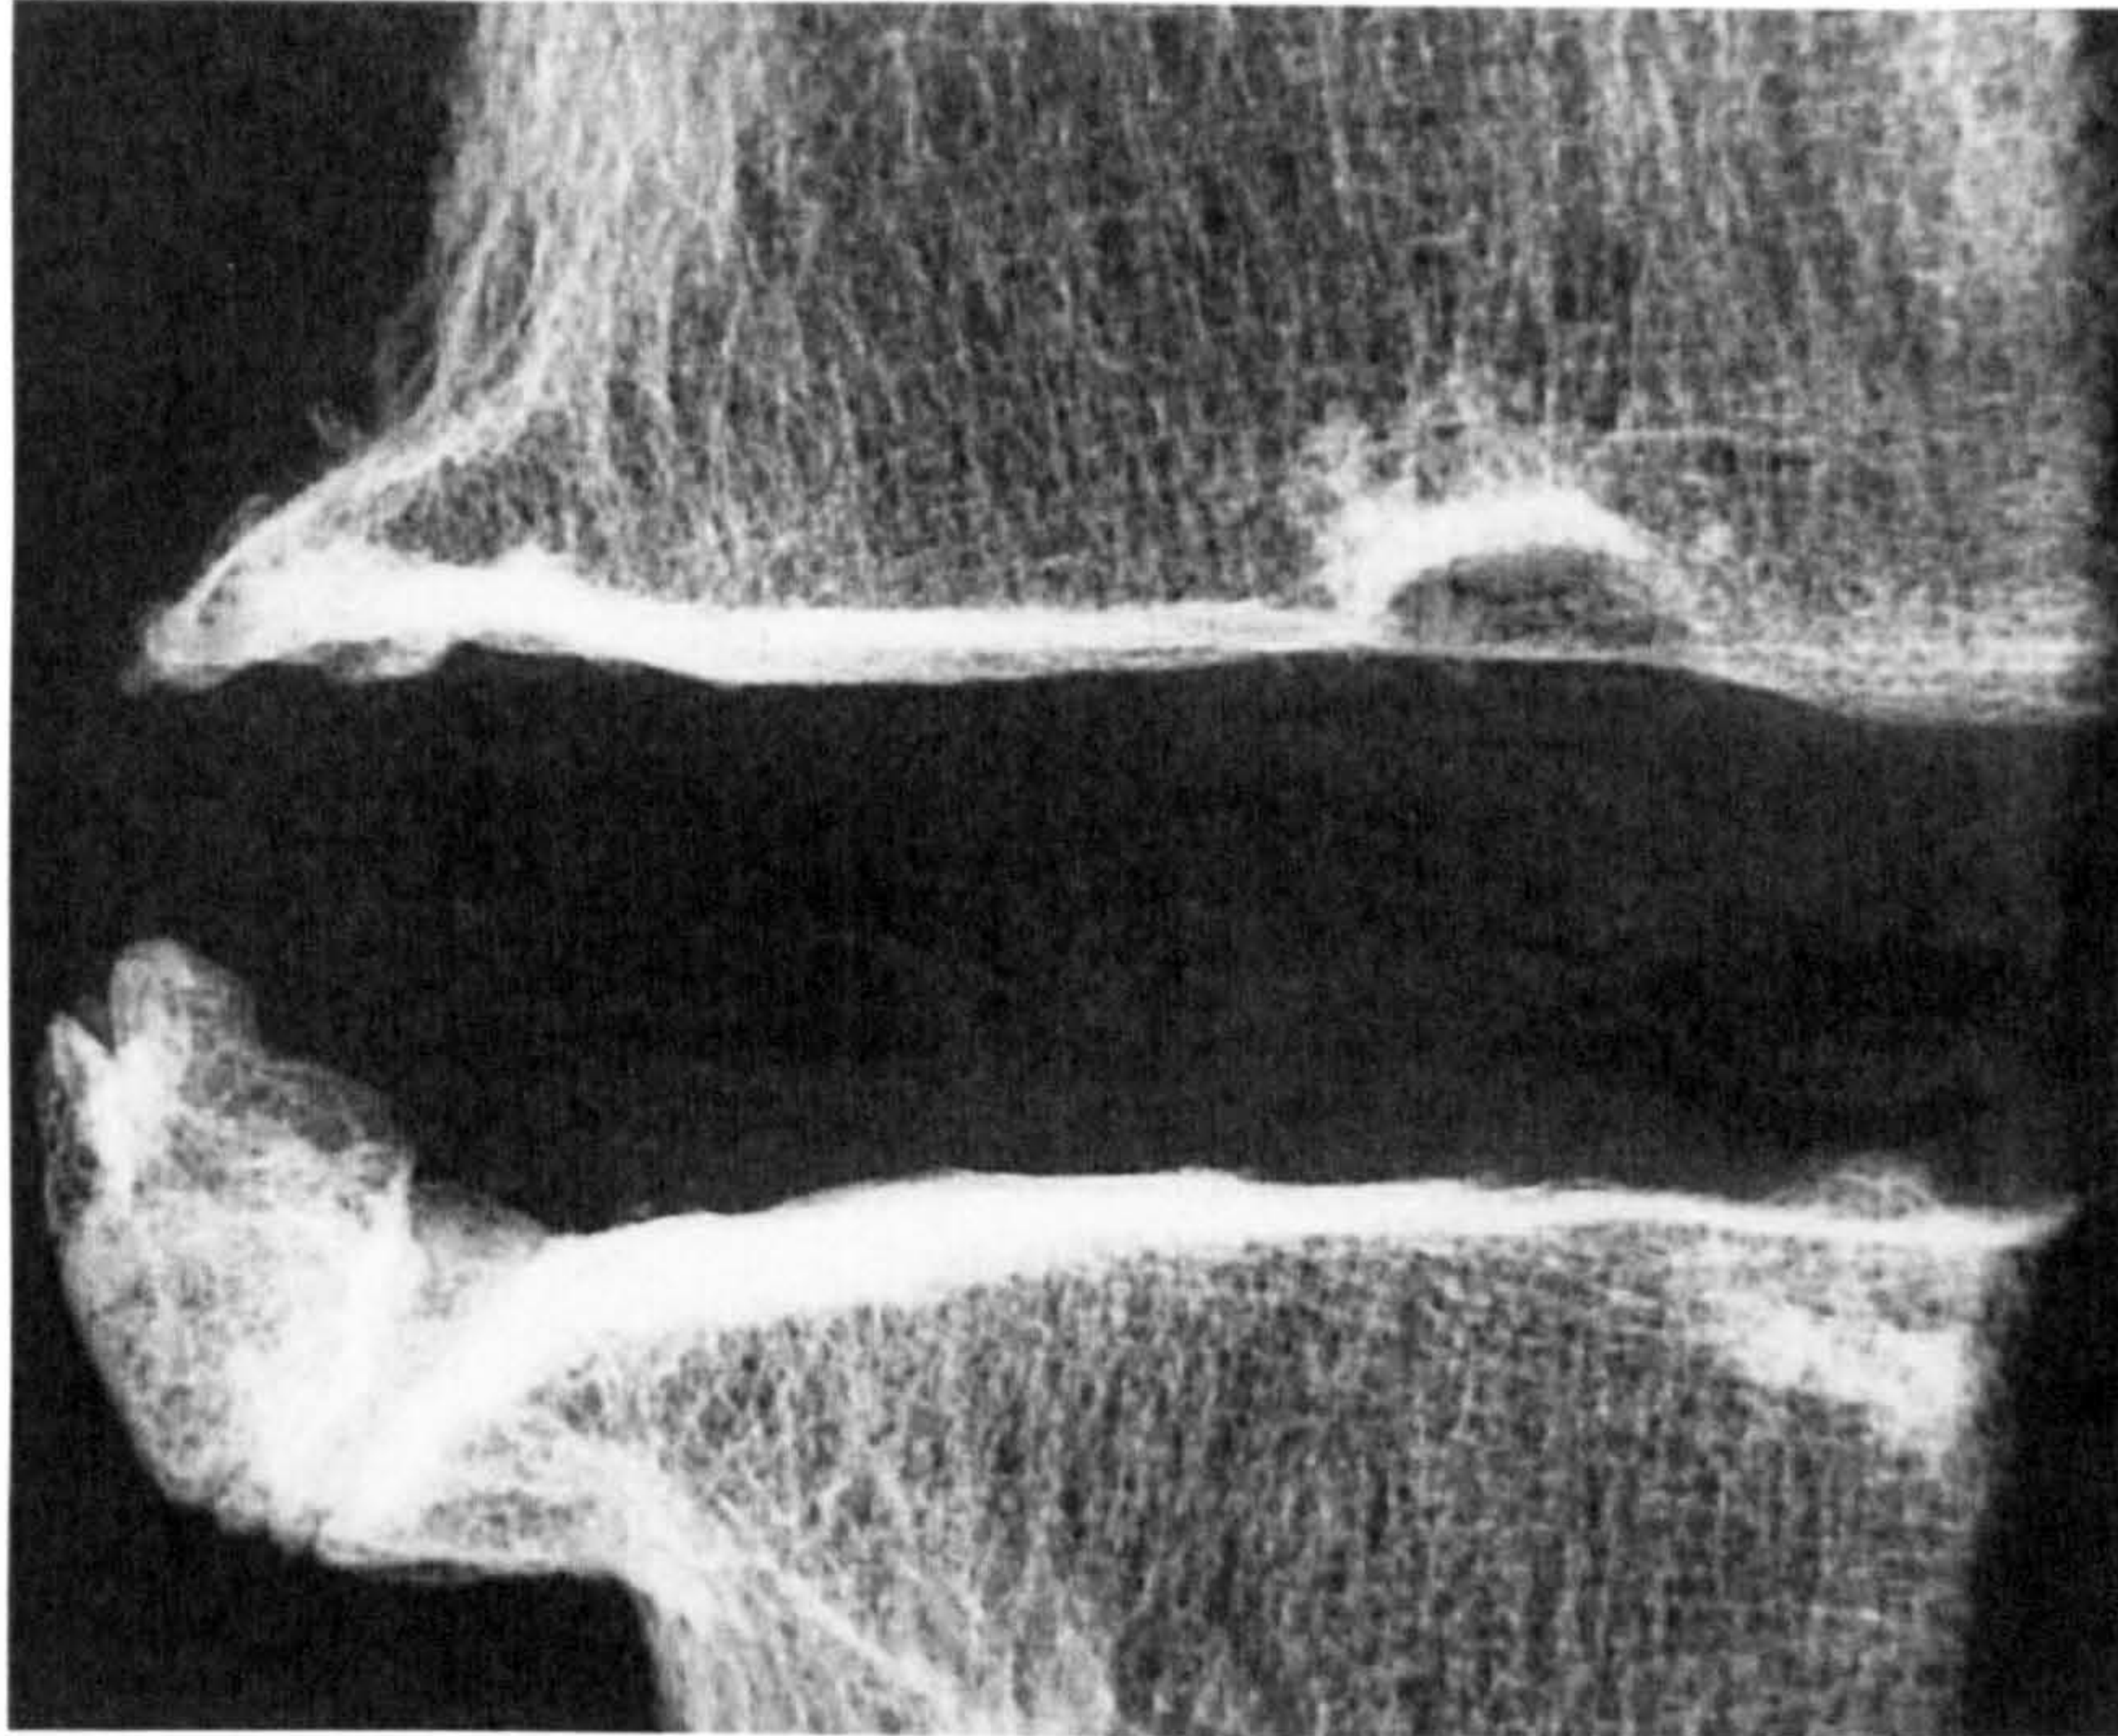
Plain radiograph of lumbar intervertebral joint osteophytes on antero-lateral border (Source: Adapted from Pfirrmann and Resnick (2001:371). Original Figure No. 6).
